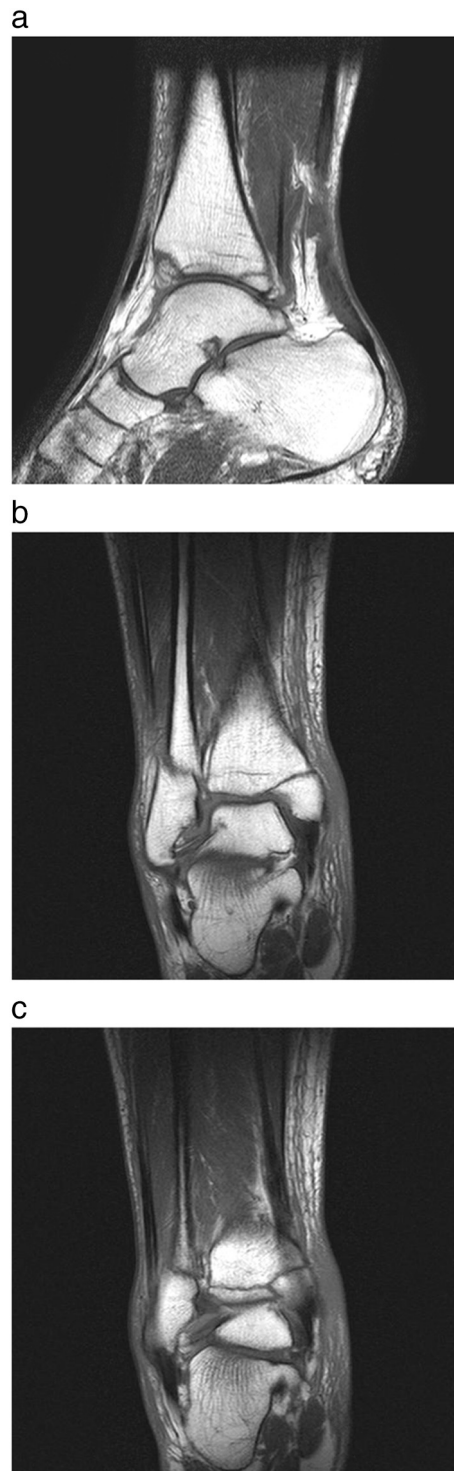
a: MRI scan of right ankle dated 9 August 2006, showing fractures of the medial and posterior malleoli and rupture of the Achilles tendon. T1WTSE, TE 20/TR 500.
